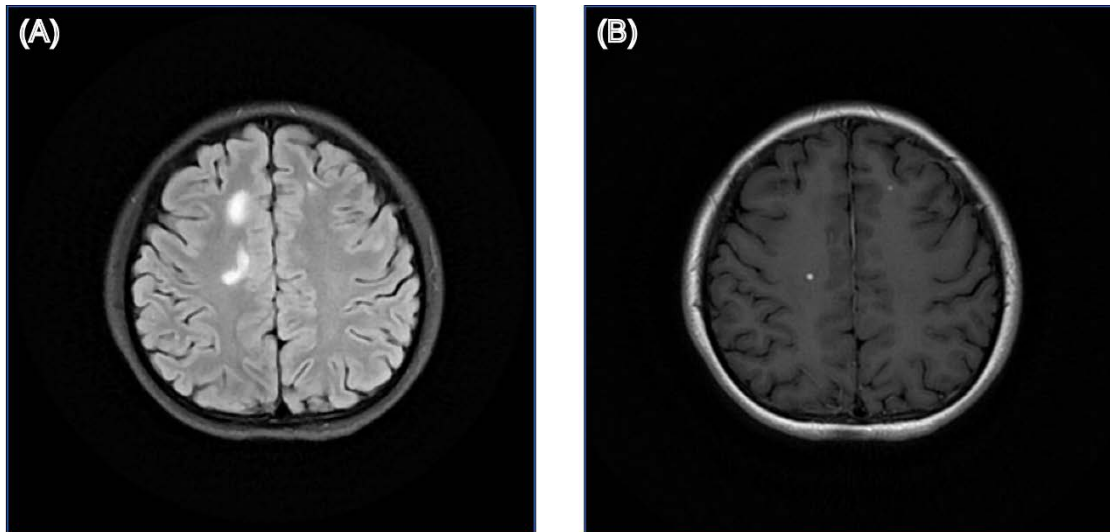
Structural brain MRI images of patient 16. (A) T2-weighted fluid-attenuated inversion recovery (T2-FLAIR) image; (B) Gadolinium-enhanced T1-weighted (Gd-T1w) image.
